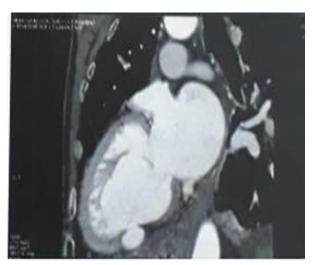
A heart CT-scan screenings visualizes the pseudoaneurysm of LV.
